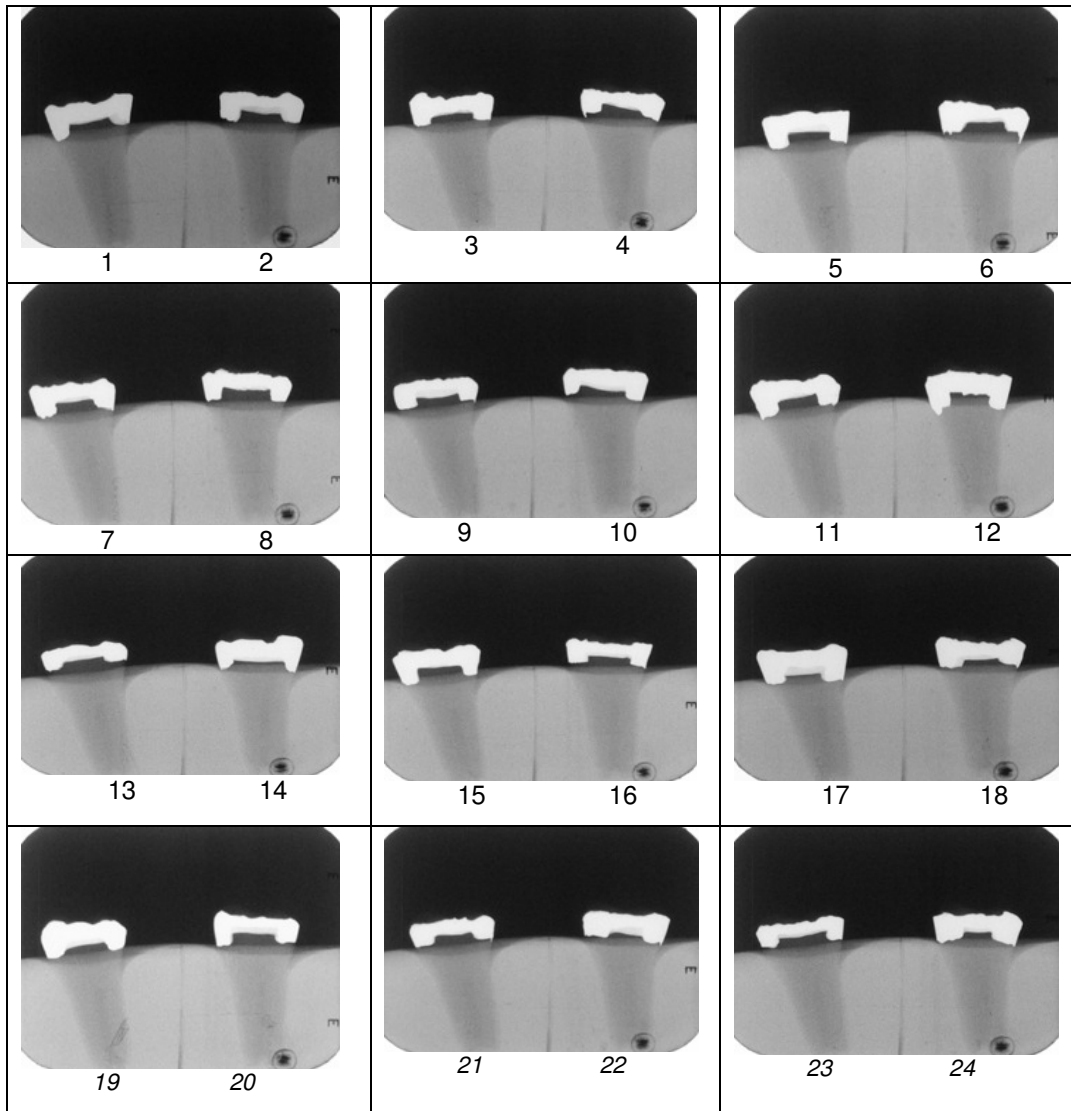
Set 1. The 'antemortem' set of 40 dental radiographs of amalgam restorations - teeth 1 to 24
